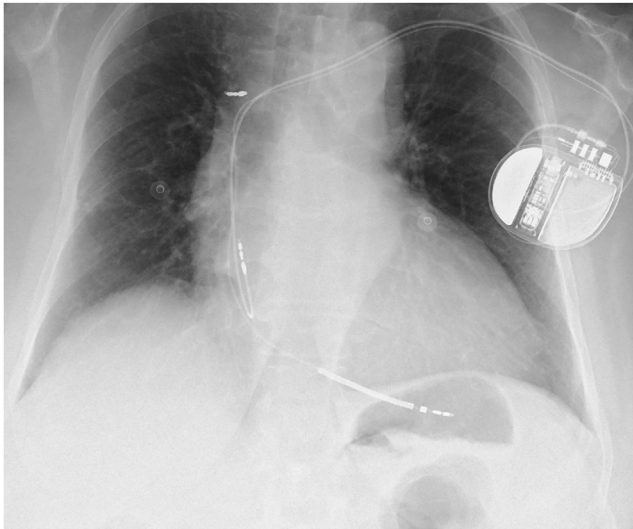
Postoperative chest radiograph with a functional DDD implantable cardioverter-defibrillator system. The tip of the extracted ventricular lead can be appreciated at the superior aspect of the superior vena cava.
